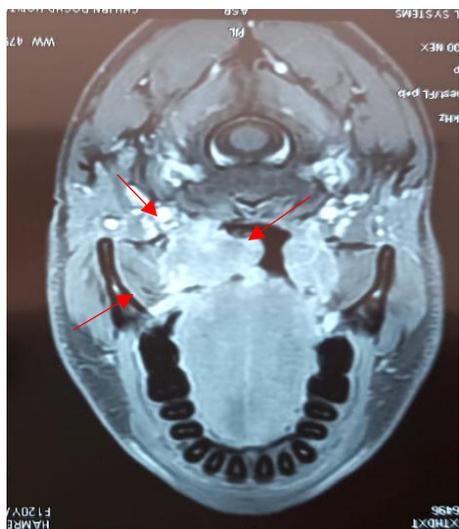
the CT MRI shows a process of the locally advanced left tonsillar region filling the oropharyngeal cavity with polylobed contours in T1 isosignal, heterogeneous hypersignal T2, heterogeneously enhanced after the injection of gadolinium 43x39mm by 41mm
